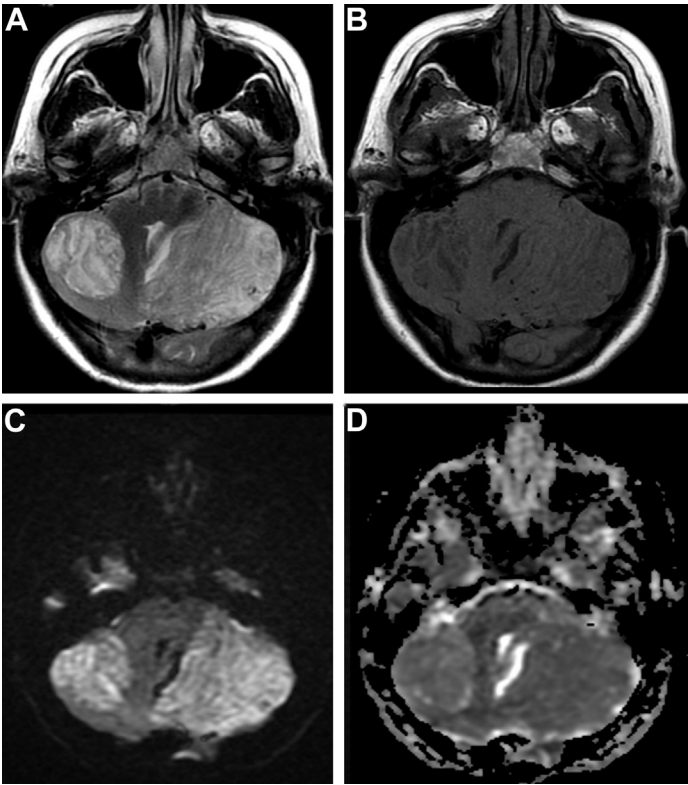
Bilateral dysplastic cerebellar gangliocytoma in a 40-year-old woman with Cowden syndrome. (A) Axial T2WI and (B) T1WI shows bilateral T2 hyperintense and T1 hypointense masses with striated appearance on T2WI. (C) Axial DWI and (D) ADC images show mild restricted diffusion in the cerebellar masses.
